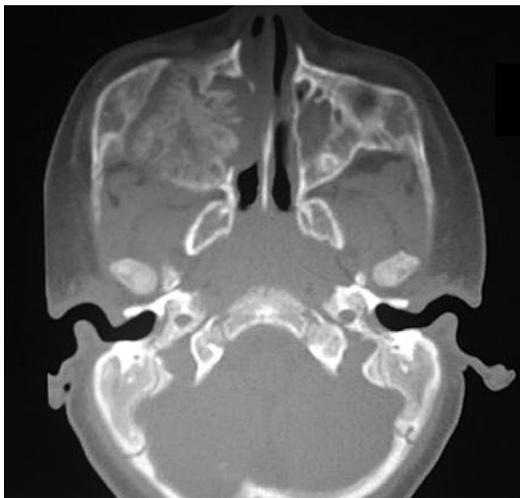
Presence of expansive mass in the maxillary sinus evidenced by CT.
